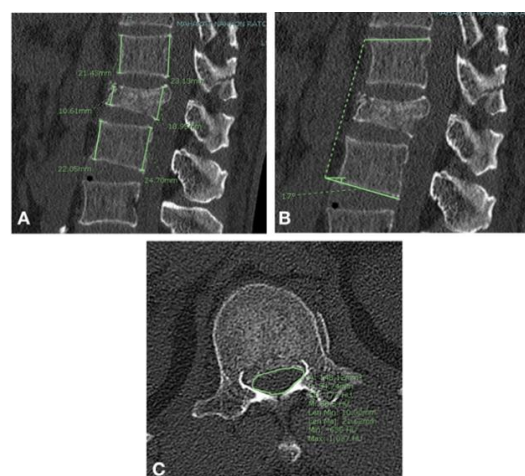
Measurements of radiographic parameters. A: Anterior vertebral height (mm.) and posterior vertebral height (mm.). B: Regional kyphotic angle. C: Central canal area.
